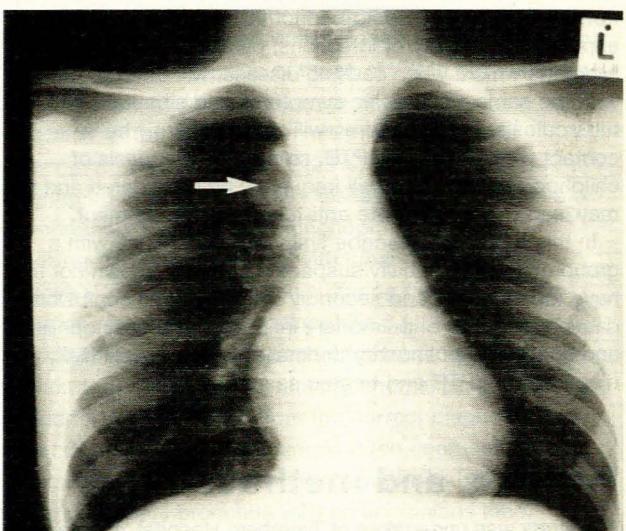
Chest radiograph (above) and CT scan (below) of an 8-year-old girl with a bronchogenic cyst (arrow) initially mistaken for paratracheal adenopathy.
